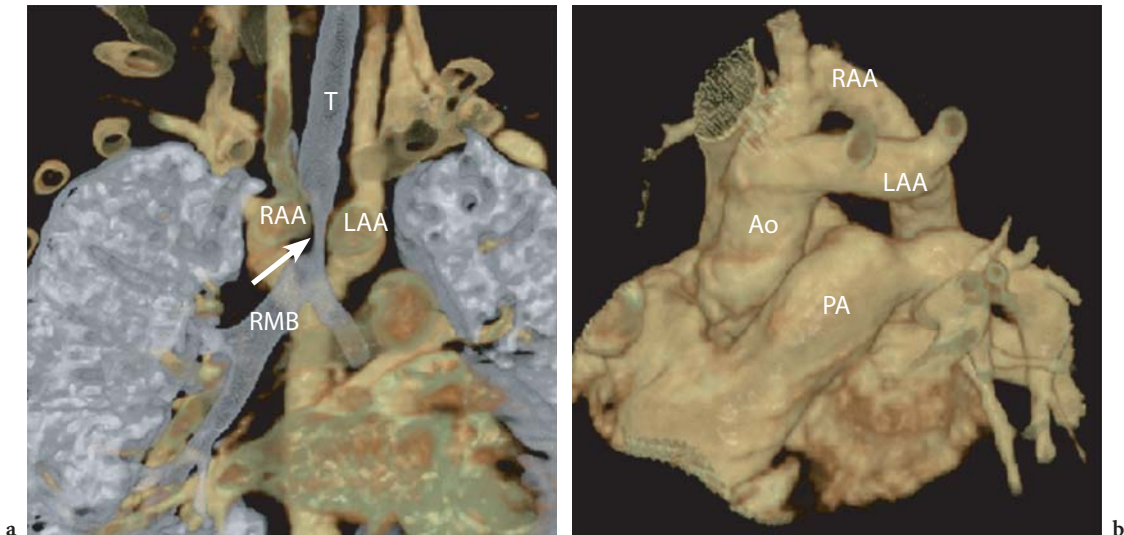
Severe respiratory distress in a newborn. a The 16-slice CT examination using VRT clearly shows a complete double aortic arch responsible for tracheal compression in a 5-month-old patient weighing 5 kg. b Using the same data set, VRT (displaying both airways and vascular structures) clearly reveals compression of the trachea (*T*) by the right aortic arch (*RAA*). *LAA* Left aortic arch, *Ao* ascending aorta, *PA* pulmonary artery
